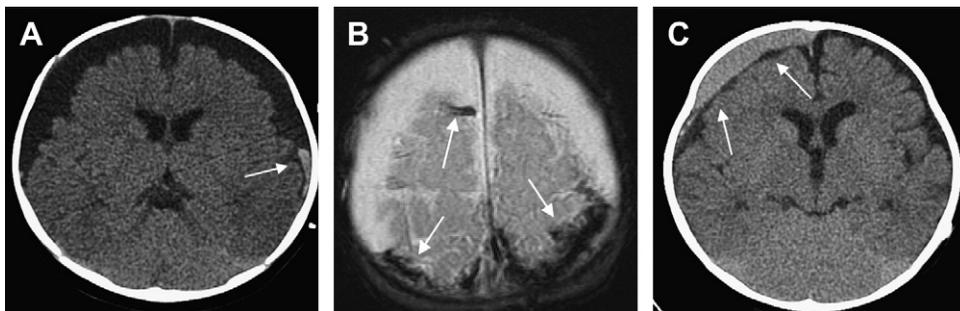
Five-month-old infant with the triad and alleged NAI; also, macrocephaly from birth, recent seizure but no trauma. CT (A) and T2* MR imaging (B) shows large extracerebral collections with smaller recent hemorrhages (arrows). CT 3 months postdrainage (C) shows rehemorrhage (arrows). Diagnosis: BECC or chronic SDHG with rehemorrhage?
